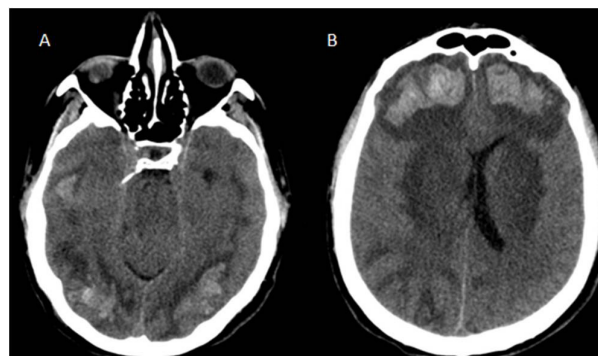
The latest nonenhanced CT shows subcortical hemorrhages (A) in the parietooccipital and (B) frontal regions.
